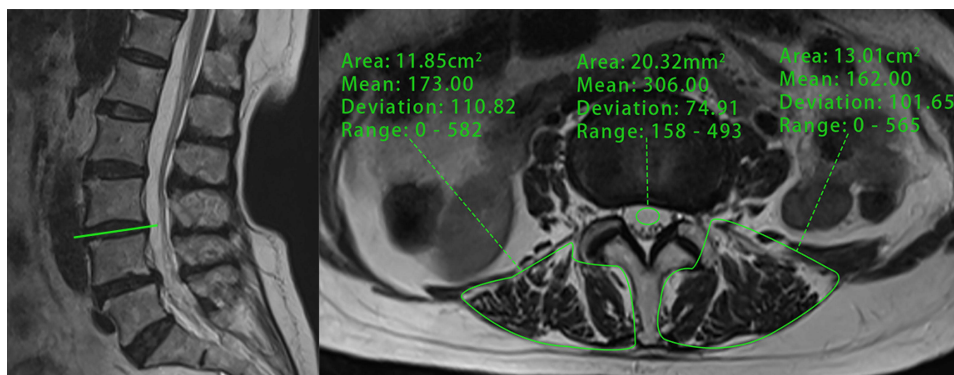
A 75-year-old woman with MRI t2-weighted images suggestive of severe muscle atrophy and more fatty infiltration of the paravertebral muscles had the signal intensity (SI) of the right and left paravertebral muscles and cerebrospinal fluid measured separately at the L3/4 disc level.
